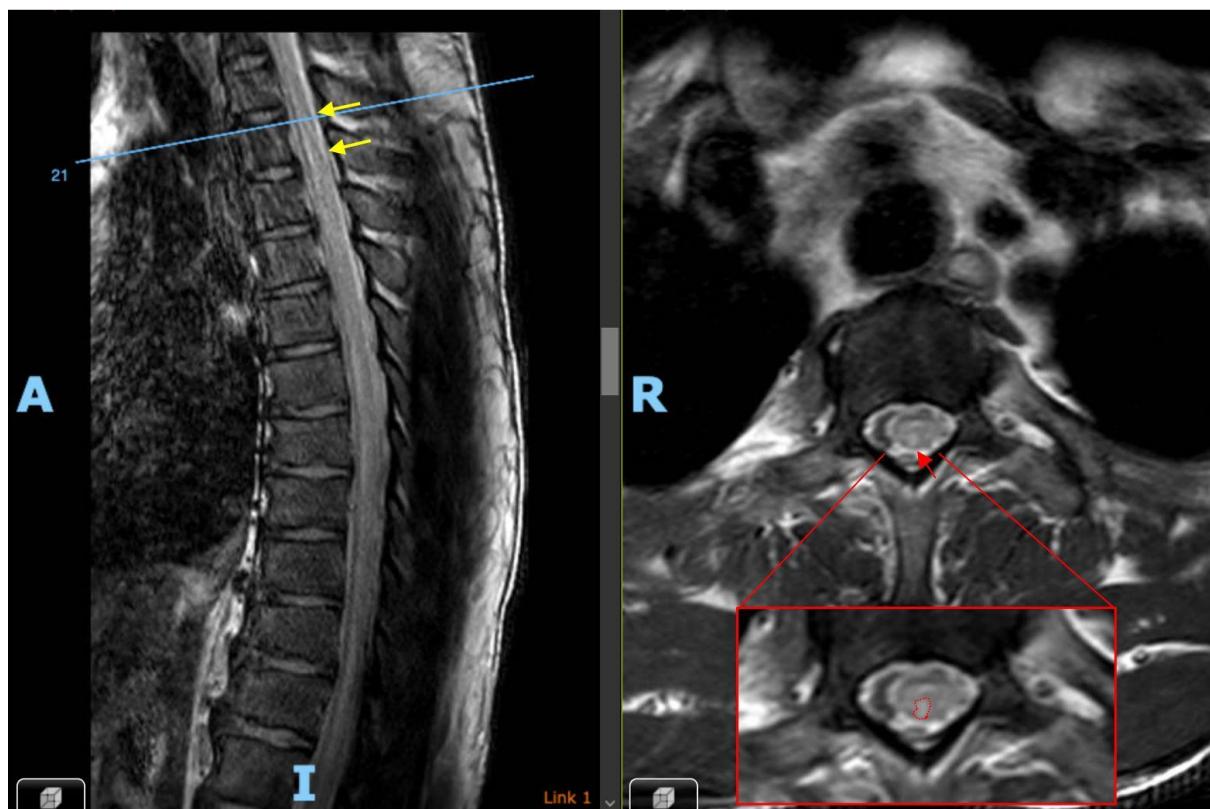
MRI T2WI showed hyper-intense lesion in posterior horn thoracic cord; left image: sagittal view (yellow arrow), right image: axial view (red arrow, dashed red area)
